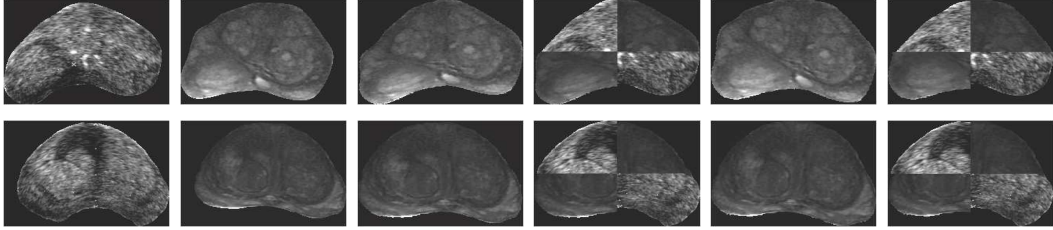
Qualitative registration results. The first two columns show the fixed TRUS and the moving MR images respectively. The 3<sup>rd</sup> and the 4<sup>th</sup> columns show the registration results for the proposed method without the deformation learning and the remaining columns show the results with the deformation learning.
